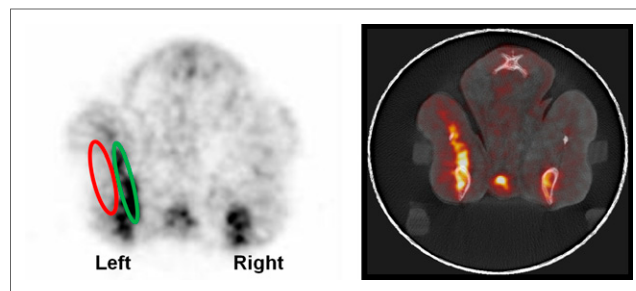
Axial images of left tibial neuropathy model. Anterolateral and posterior compartment are drawn with red and green circles, respectively. Only posterior compartment muscles show increased ^{18}F -FDG uptake, compared with Figure 1A.
